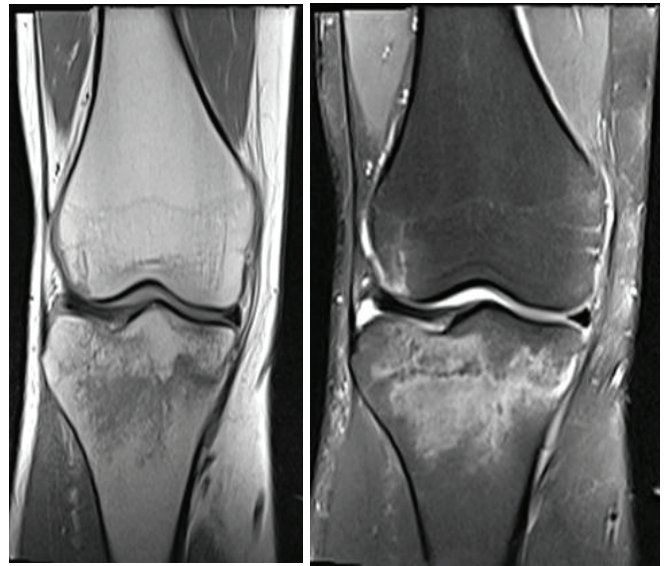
(Osseous Injury): PD Cor & T1 Cor MR image in a 23-year-old male Basketball player shows a non-displaced fracture of medial tibial plateau with significant marrow edema and minimal marrow edema at lateral femoral condyle with small joint effusion.
